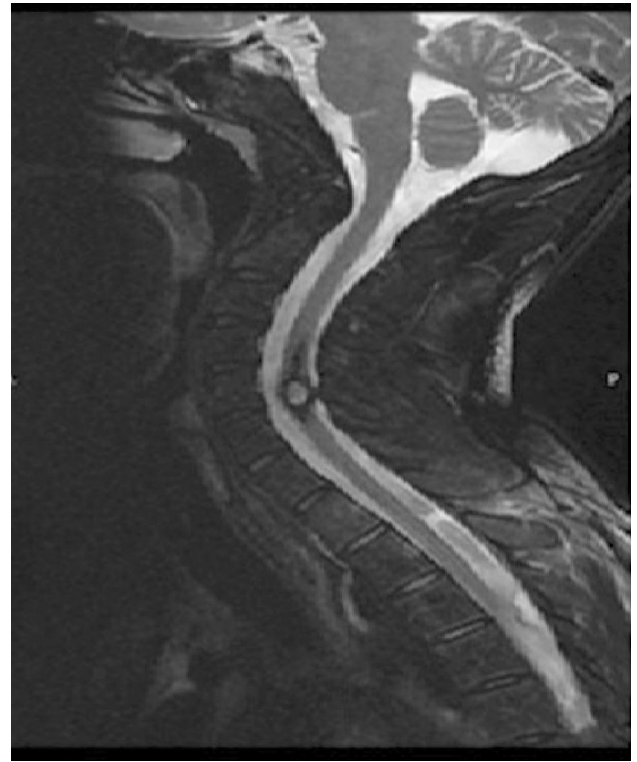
T2-weighted fatsat sagittal image: The mass shows peripheral low signal intensity rim of hemosiderin
